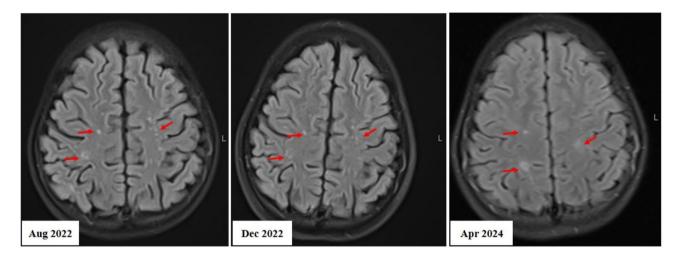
Brain of MRI. Red arrow: demyelinating lesions
